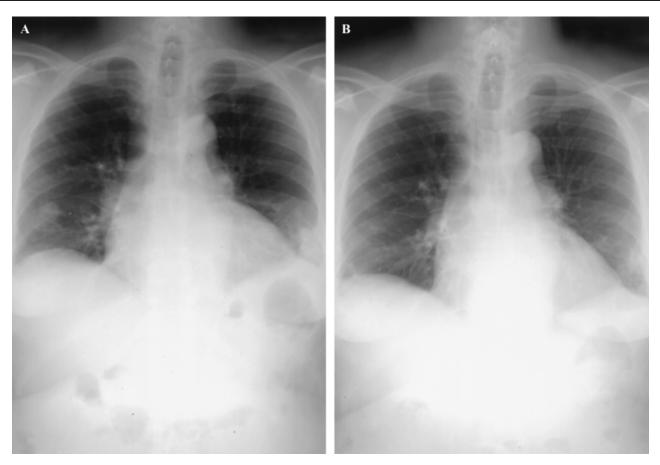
A, Chest radiograph of Patient 3, December 1999. Multiple large nodules are present in the left lung base and a single large nodule is apparent in the right lung base. A cavitating lesion is present in the right midzone. B, Chest radiograph of the same patient, November 2000, demonstrating resolution of pulmonary nodules and cavitatary lesions with residual scar formation.
